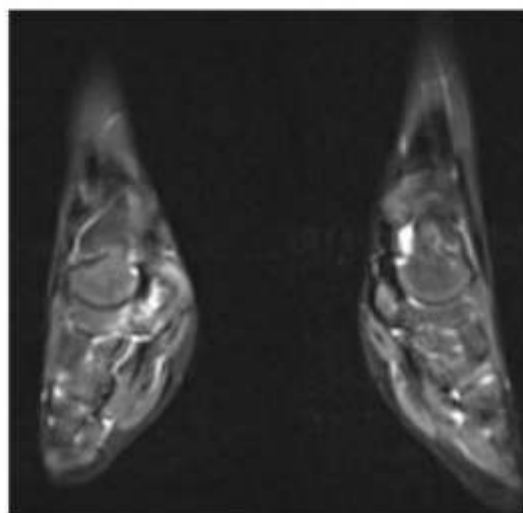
Bone marrow edema in the right navicular bone on whole-body MRI, the high signal intensity on the left is consistent with visualized vessels
